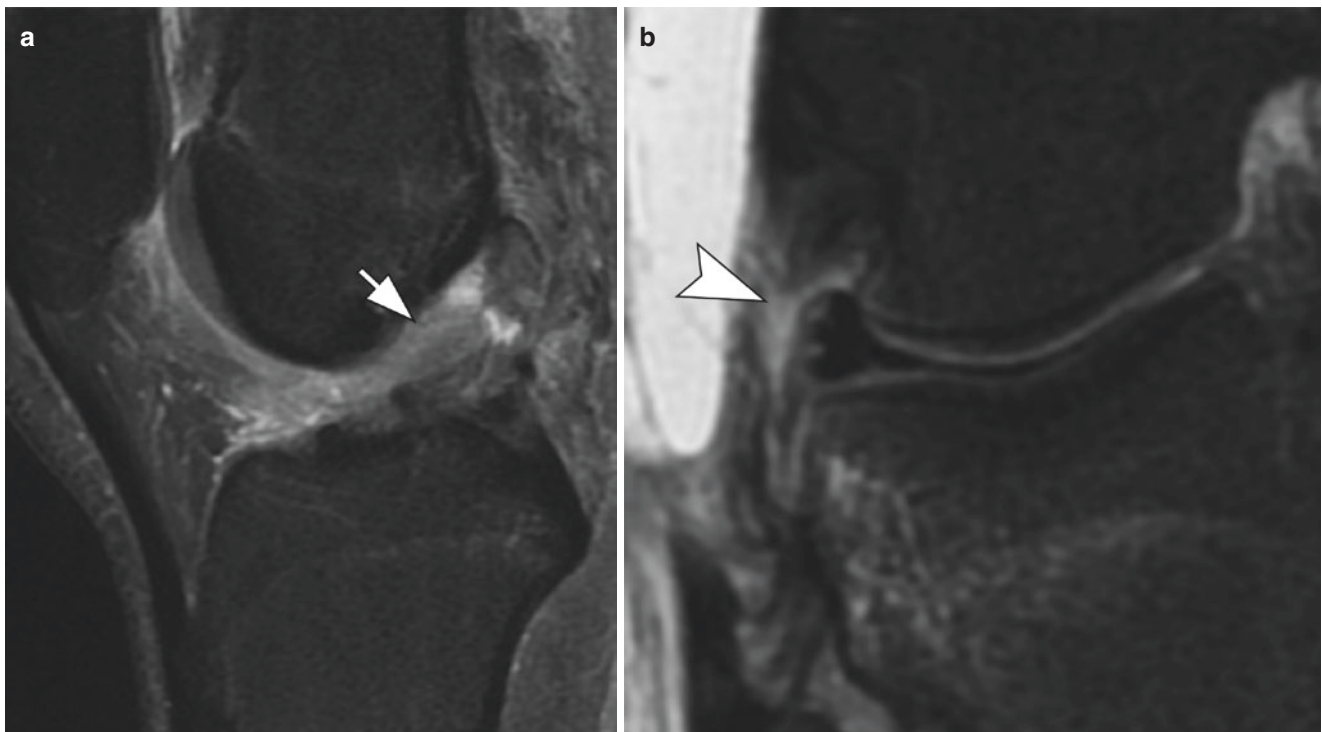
Associated anterolateral and ACL tears. (a) Sagittal T2-weighted image with fat suppression showing an ACL tear (arrow). (b) Coronal T2-weighted image with fat suppression demonstrates a complete tear of the ALL (arrowhead)
